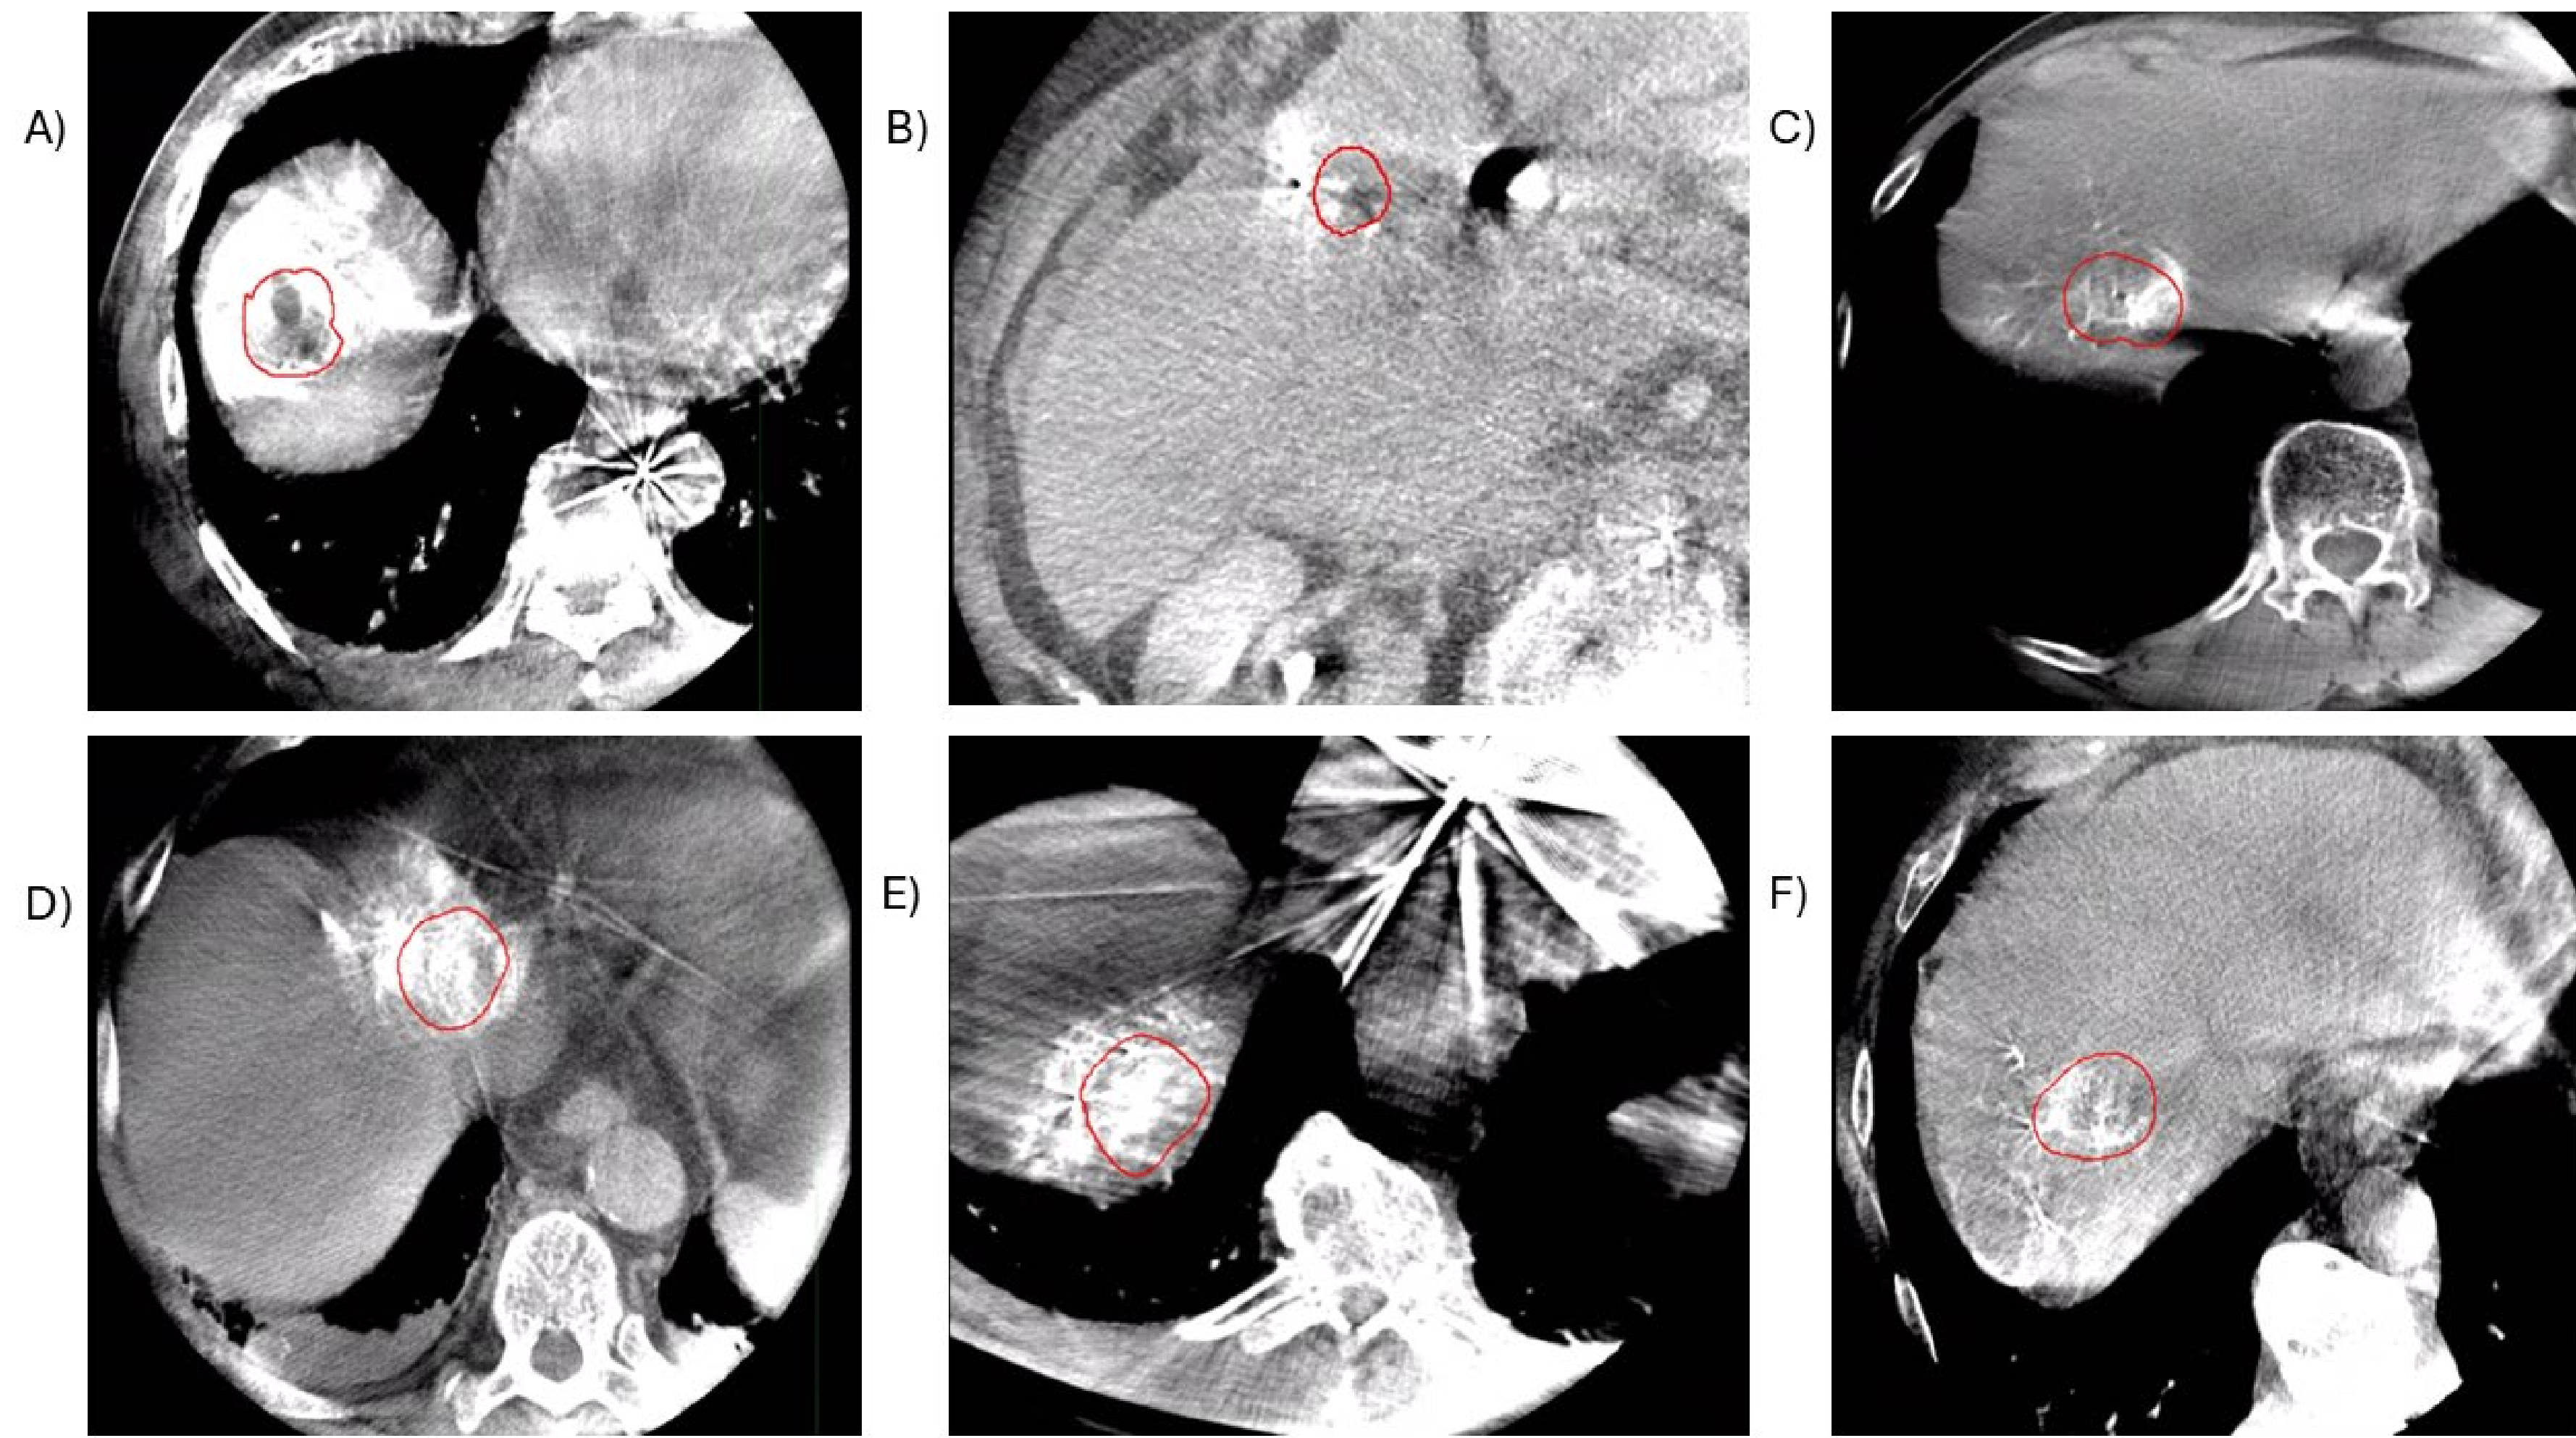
CBCT images for several patients with similar GTV volumes. The red line outlines the gross tumor volume (GTV) derived and transferred from the most recent diagnostic imaging. Patient A) had RLV above cutoff, GTV volume 15.79cc, and was a non-responder. Patient B) had RLV value below the cutoff, GTV volume 25.70cc, and was a responder. Patient C) had RLV value below the cutoff, GTV volume 26.65cc, and was a non-responder. Patient D) had RLV value above the cutoff, GTV volume 17.78cc, and was a responder. Patient E) had RLV value above the cutoff, GTV volume 17.71cc, and was a responder. Patient F) had RLV value above the cutoff, GTV volume 20.65cc, and was a responder.
